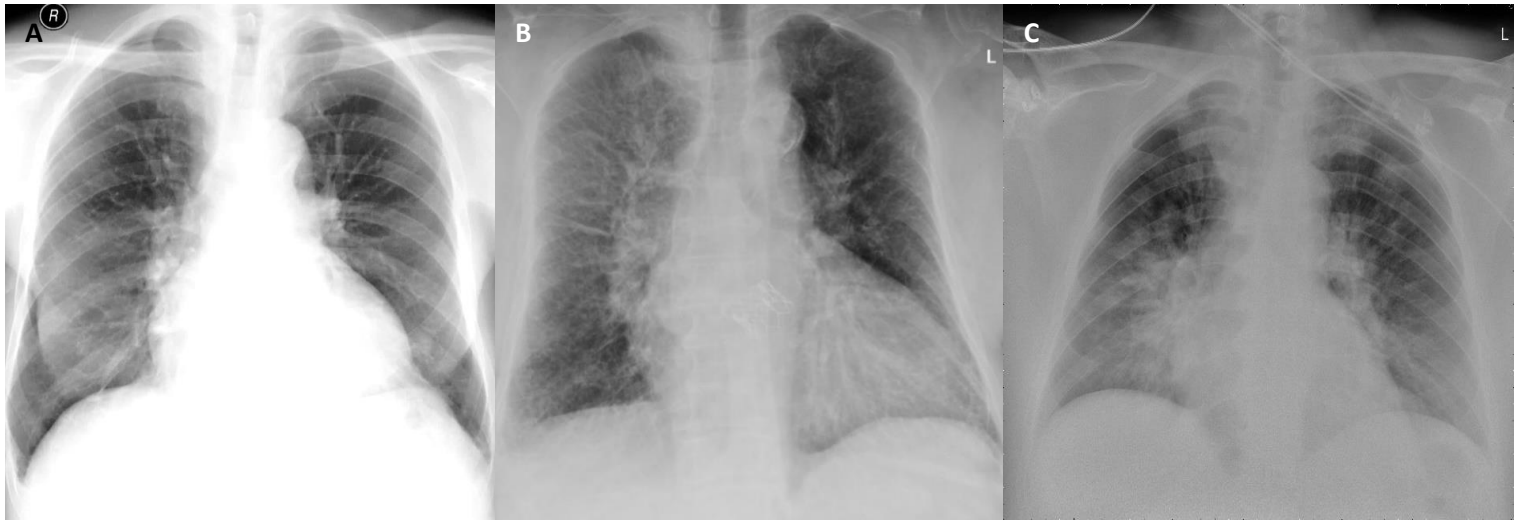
A - Chest X-ray, upright, heart congestion 1st degree, increased size of upper lobe vessels due to blood redistribution, dilated heart shadow.
